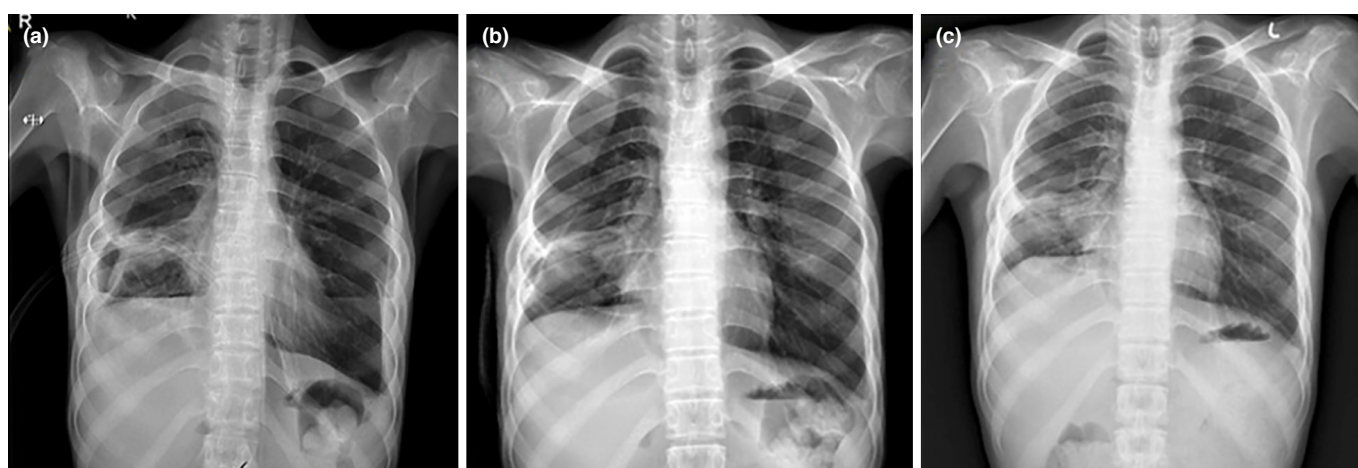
Chest X-ray after the PR program at 2 months, 3 months, and 6 months. (a) Chest X-ray at 2 months after the PR program; (b) Chest X-ray at 3 months after the PR program; (c) Follow-up chest X-ray at 6 months after the PR program
